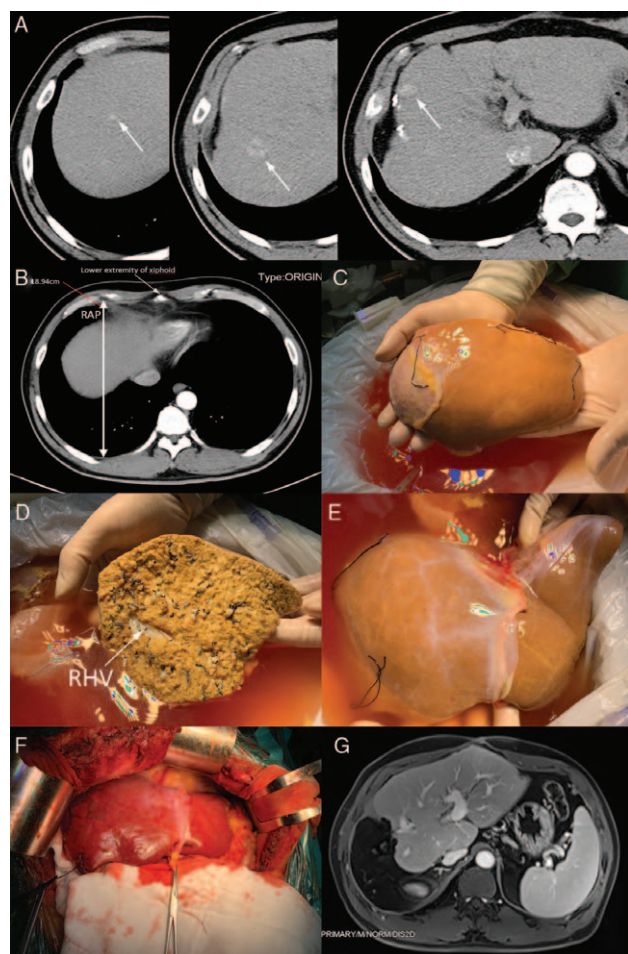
(A) Recipient's multiple recurrent hepatocellular carcinomas (arrow) on CT scan. (B) The right anteroposterior vertical distance between anterior and posterior parts of the ribs at the level of the xiphoid (arrow) process on CT scan. (C) Reduction of the right posterior section from the liver graft. (D) Preservation of the right hepatic vein (arrow). (E) The remaining liver graft. (F) Implantation of the reduced-size liver graft into the recipient. (G) Magnetic resonance imaging showing no recurrence at 10 months of follow-up.
